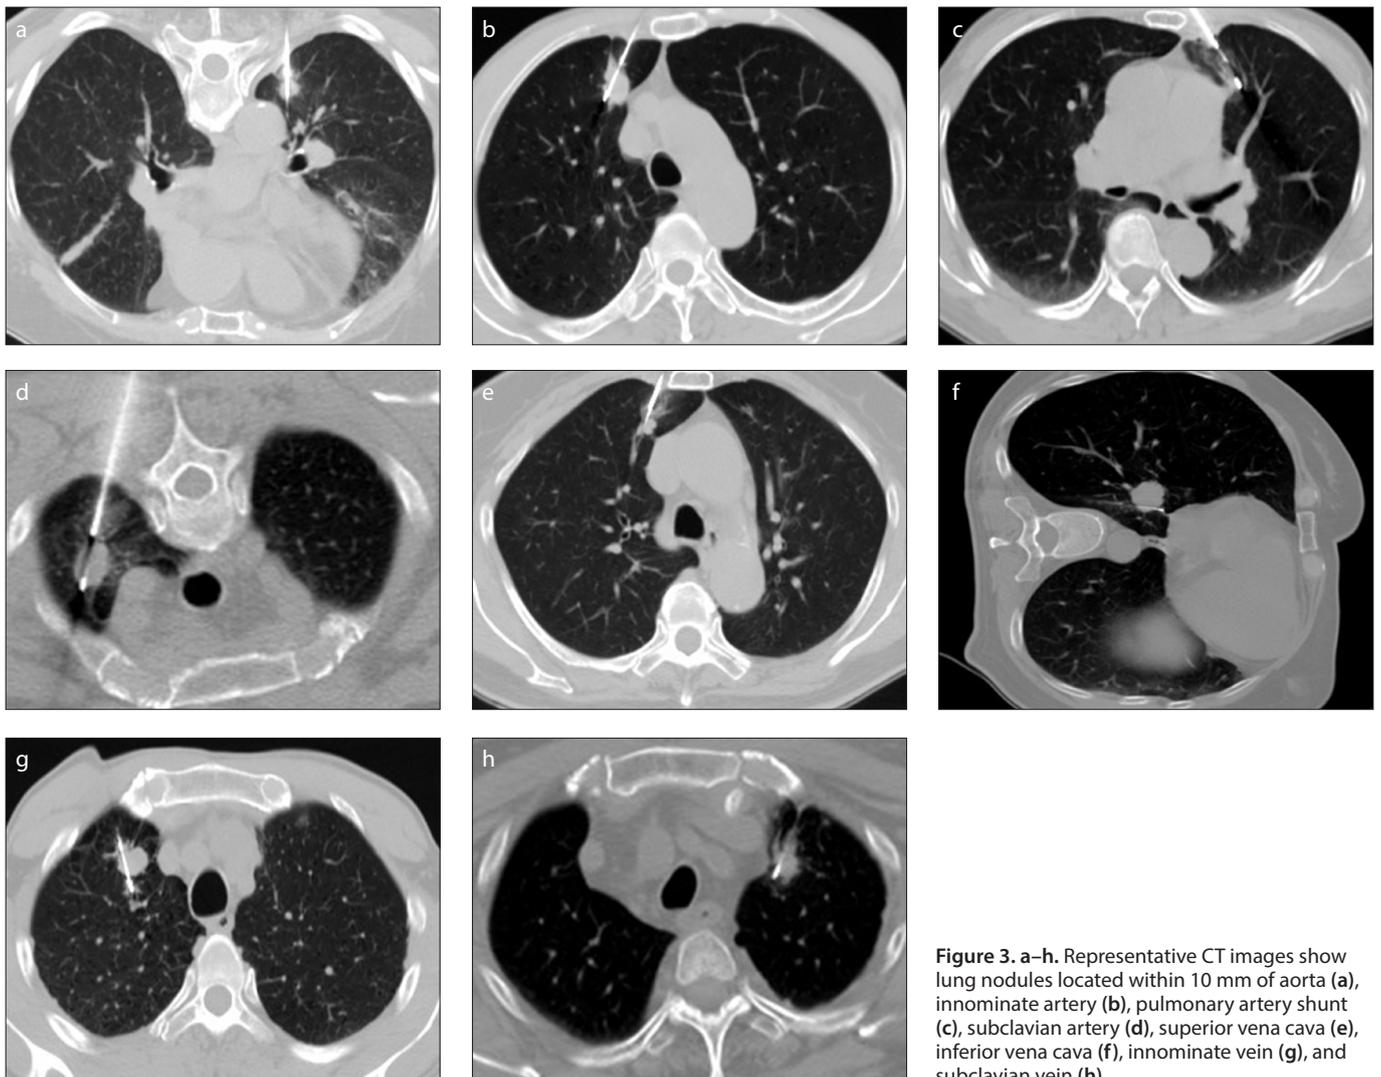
a–h. Representative CT images show lung nodules located within 10 mm of aorta (a), innominate artery (b), pulmonary artery shunt (c), subclavian artery (d), superior vena cava (e), inferior vena cava (f), innominate vein (g), and subclavian vein (h).
